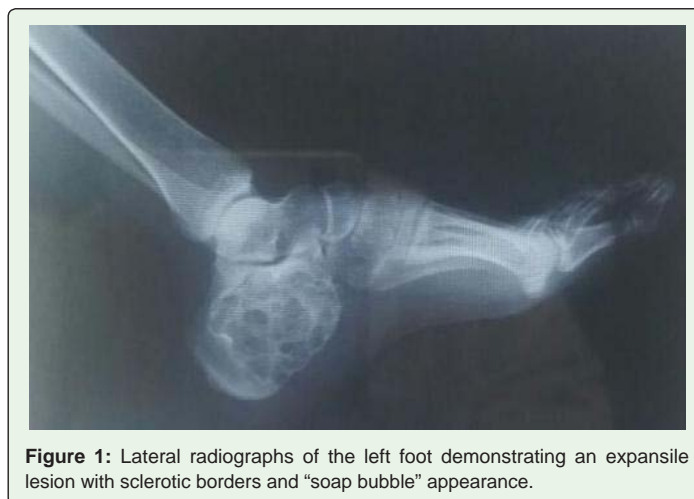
Lateral radiographs of the left foot demonstrating an expansile lesion with sclerotic borders and “soap bubble” appearance.
